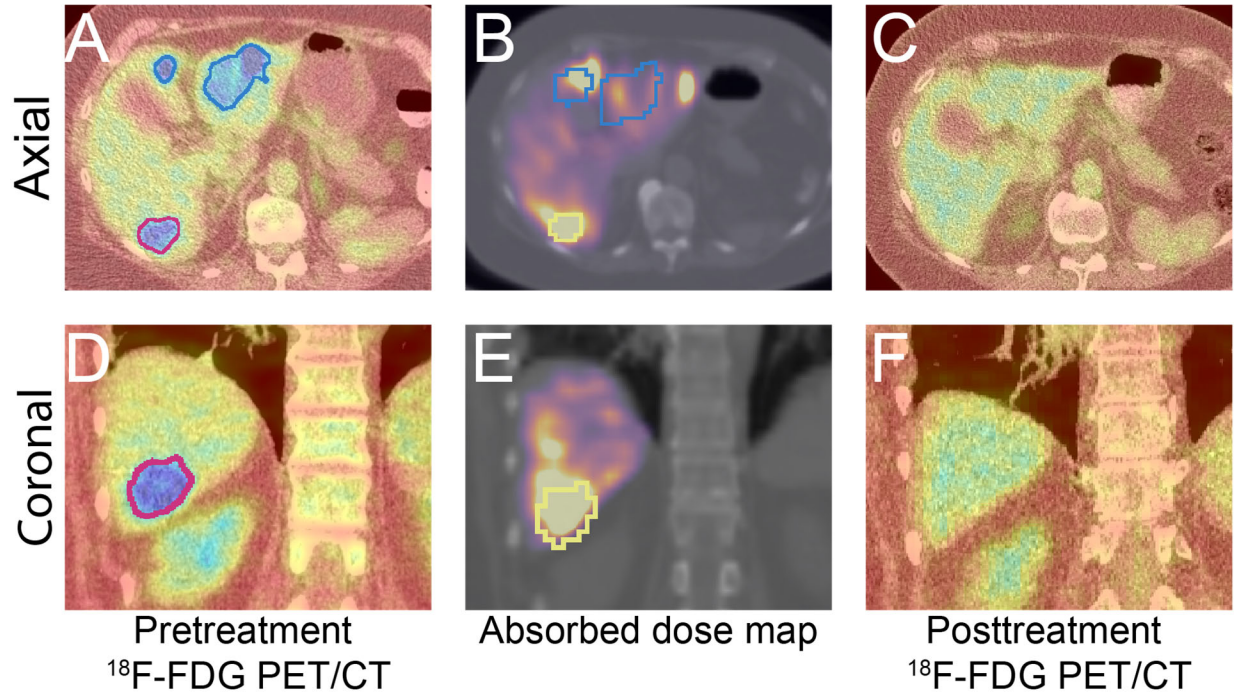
Exemplar case in which good spatial correspondence between pretreatment tumor metabolism (A and D) and absorbed dose (D_{avg} 120 Gy) (B and E) led to a complete response (C and F). Tumor outlines are transferred from the pretreatment FDG-PET/CT to the Absorbed dose maps through rigid registration of the appurtenant CTs of the SPECT/CT and FDG-PET/CTs. In many cases, this registration is imperfect, resulting in slight registration errors, such as evident in panel B.
